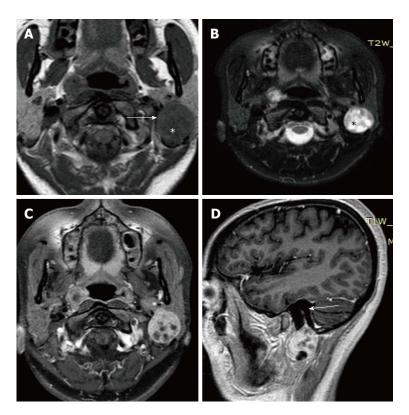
Magnetic resonance imaging images at the level of parotid glands-axial T1W (A), axial T2W (B), Post Gad T1W images in axial (C) and sagittal (D)planes. Arrow in (A) shows presence of well defined intermediate signal intensity mass lesion in the superficial lobe of left parotid with hypointense areas within it (*). These regions (*) are hyperintense on T2W sequence (B) suggestive of myxomatous tissue.On Post contrast images (C and D), the mass enhances homogeneously with few non enhancing areas within. Arrow in D shows the characteristic "string sign" extending along with facial nerve in the stylomastoid foramen.
